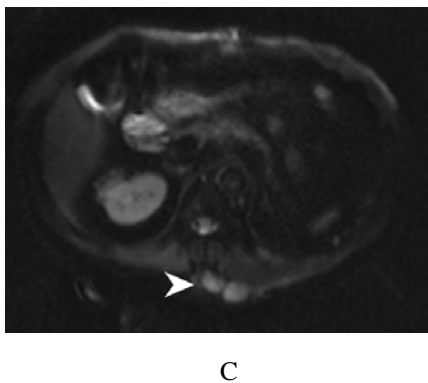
Abdominal MR Axial DWI (C) and T1 post-contrast Fat-sat images (D, E): subcutaneous nodular lesions are showing high signal on diffusion-weighted images (C. white arrowhead), homogeneously enhanced multiple subcutaneous nodular lesions (D. white arrowhead) and left pleural-based nodular lesion (E. white arrowhead) after contrast administration
